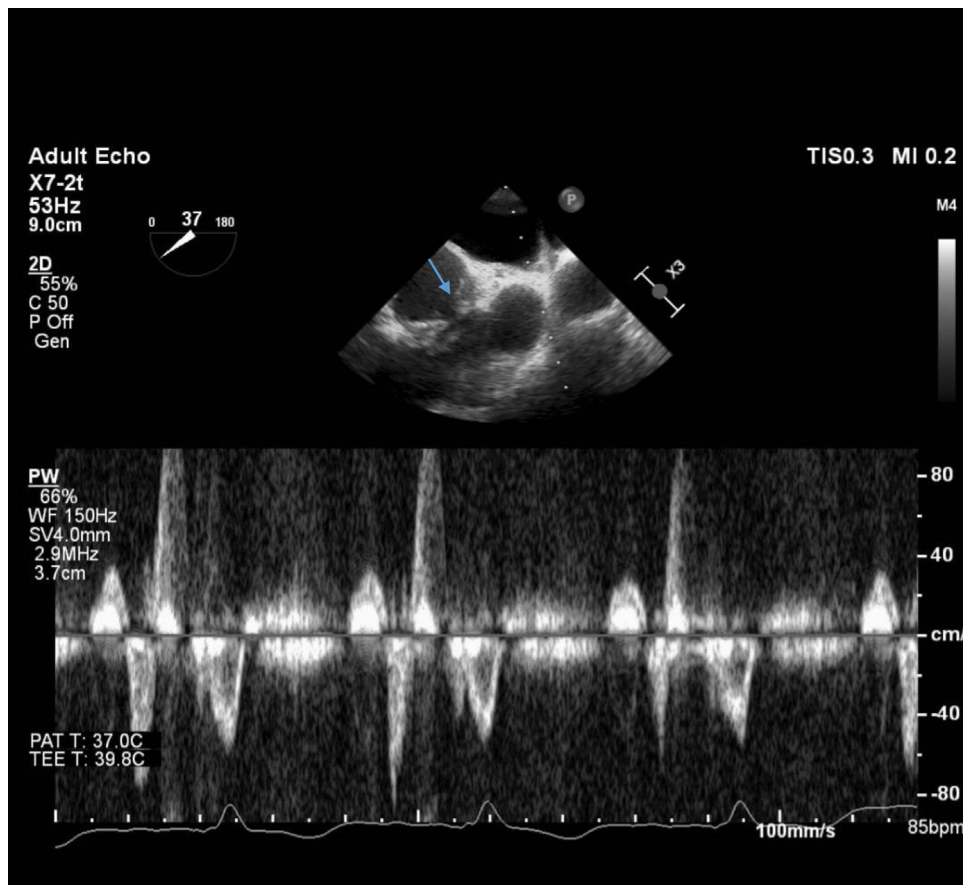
Transesophageal echocardiography showing moderate regurgitation of the pulmonary valve prosthesis with accompanying vegetations (blue arrow).
